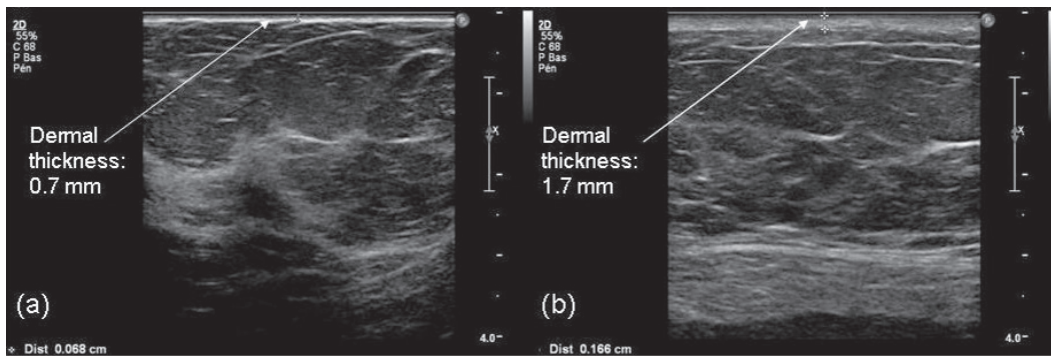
Ultrasound examination: (a) normal appearance of unaffected side contrasting (b) with oedema located within the dermis and hypodermis of affected side.
